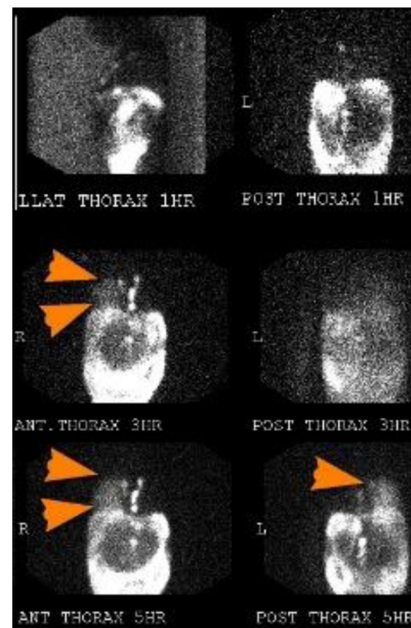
Delayed planar images of the peritoneal scintigraphy found diffuse tracer activity at the right hemithorax (orange arrowheads)
